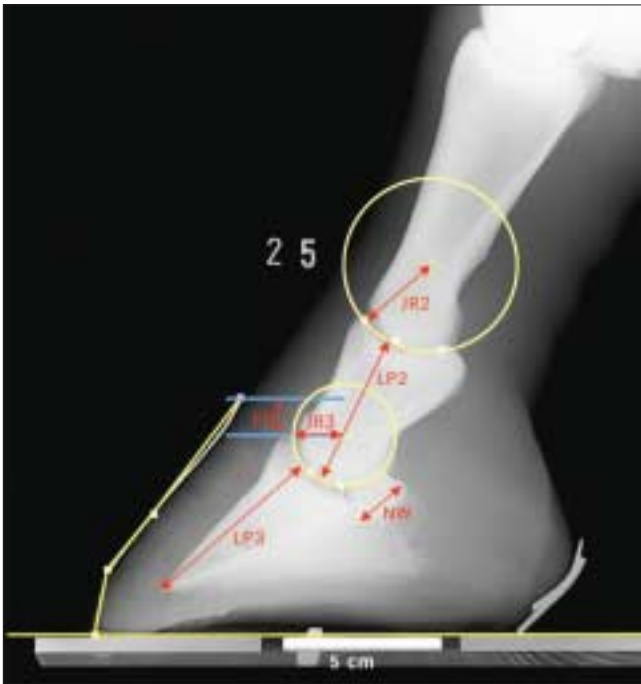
Bone parameters of the laterolateral radiograph. JR2: P1-P2 joint radius, distance from the centre of rotation to the articular surface. JR3: P2-P3 joint radius, distance from the centre of rotation to the articular surface. LP2: Length of P2, the distance between the two rotation centres of the distal interphalangeal joints minus P1-P2 joint radius (JR2) and plus P2-P3 joint radius (JR3). LP3: Length of P3, from the tip of P3 to the centre of rotation of the distal interphalangeal joint minus P2-P3 joint radius (JR3) NW: Navicular bone width, the width of the navicular bone (maximum width as seen on this view). FD: Founder Distance is the P3 descent. Distance between two horizontal lines through the hairline and the top of extensor process of P3, respectively. It is a measure of the height of P3 in the hoof capsule.
